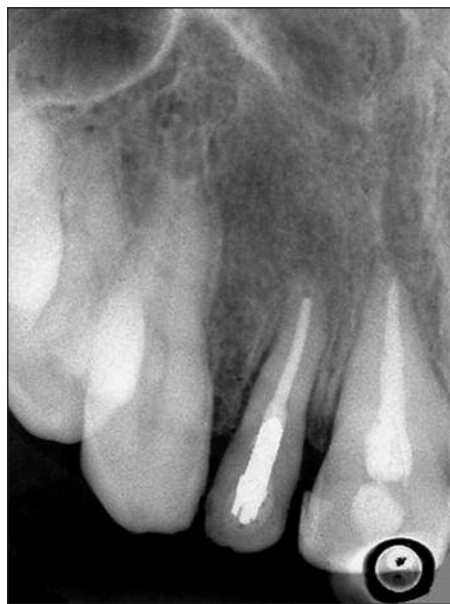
The radiographic image of the tooth after the root canal treatment and the placement of the metal post.
